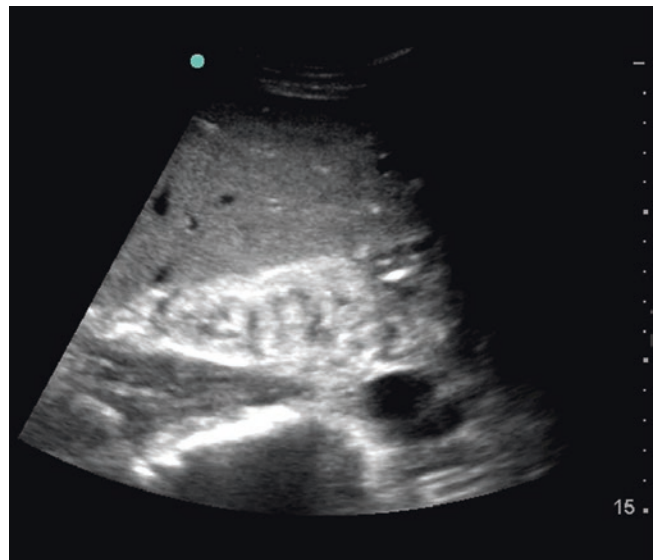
Ultrasound image of chronic renal failure. Kidneys in chronic failure appear shrunken and demonstrate cortical thinning. (Image courtesy of Bret Nelson.)
